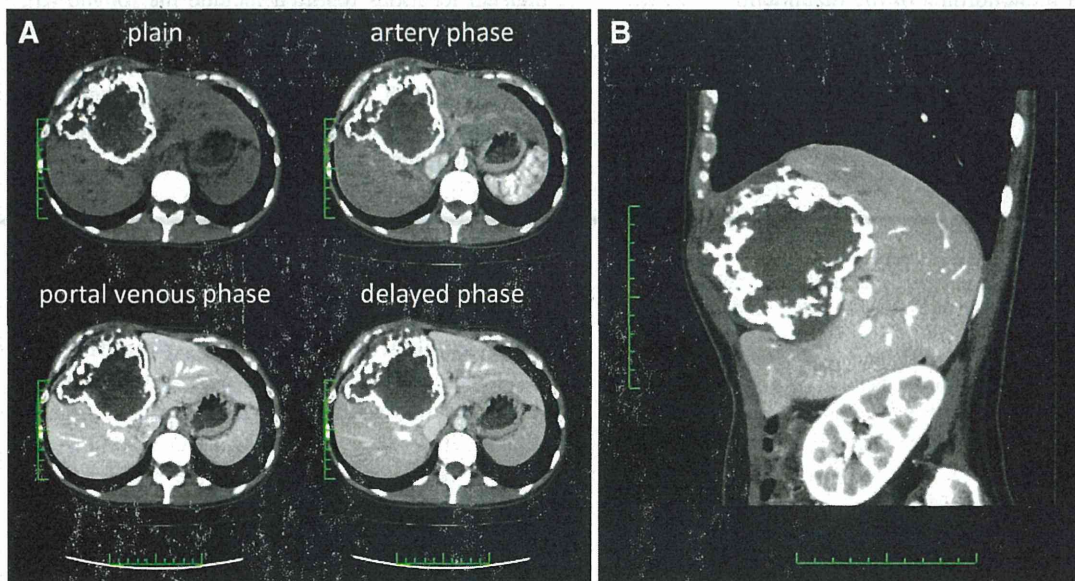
a Dynamic computed tomographic (CT) images of the liver, showing a 10.7×9.8 cm tumor in the right anterior and left medial sections. The tumor was covered with a calcified layer, but was not enhanced by contrast agent in any phase, suggesting that there was no
